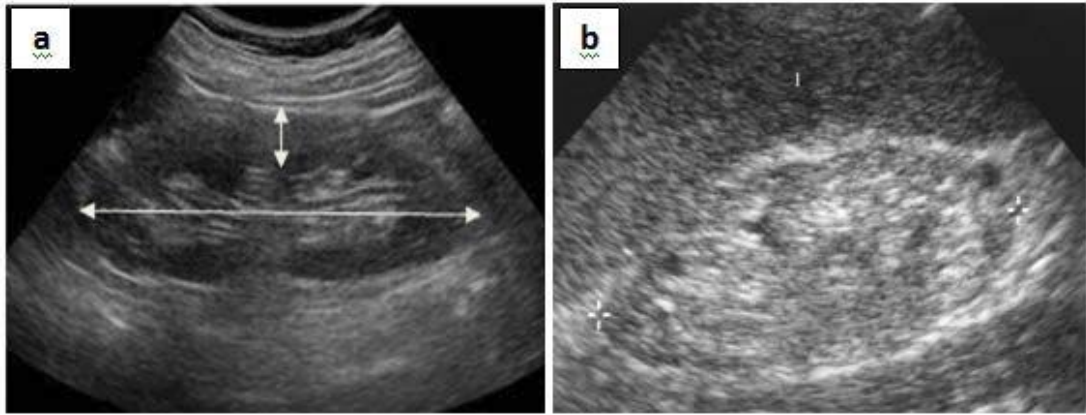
The sonographic appearance of diabetes impact in renal morphology: (a) cortex enlargement and atrophied medulla and the renal enlargement greater than 14.5cm; (b) late case in which the kidney is more echogenic with loss of corticomedullary differentiation, the patient requiring dialysis or kidney transplantation. (F. Fiorini, L. Barozzi).
